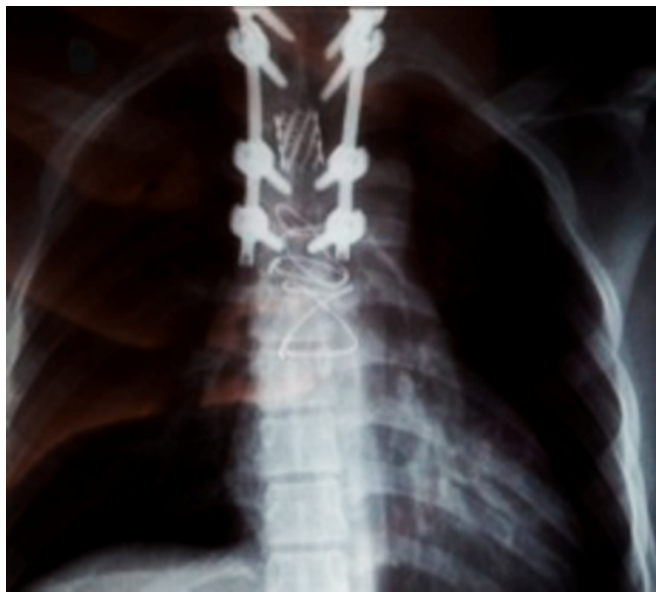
Anteroposterior radiograph of the thoracic spine after the second surgery, showing T3 total corpectomy, vertebral fusion and positioning of the Cage of Harms longitudinally supporting the proximal and distal vertebral plateaus, restoring the anterior column
